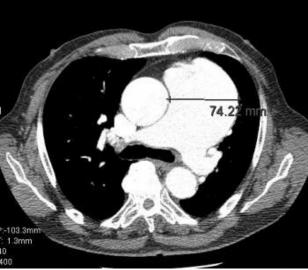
CT scans of the chest showing a tumor in the left hilum. LUNG CANCER
